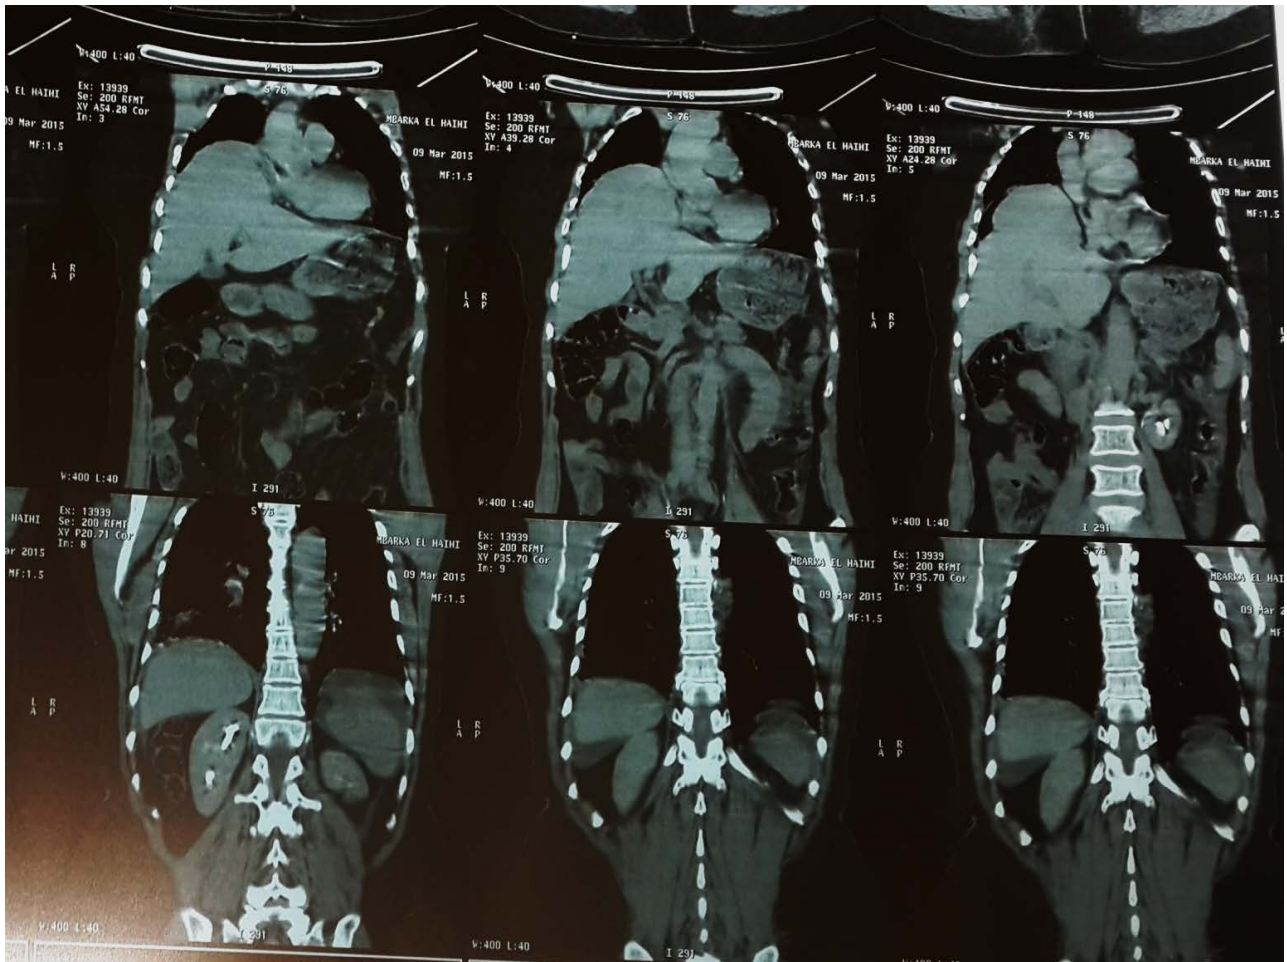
Thorax and abdominal CT showing the dislocation of the liver with compression of the right lung and shift of the mediastinum to the left.
